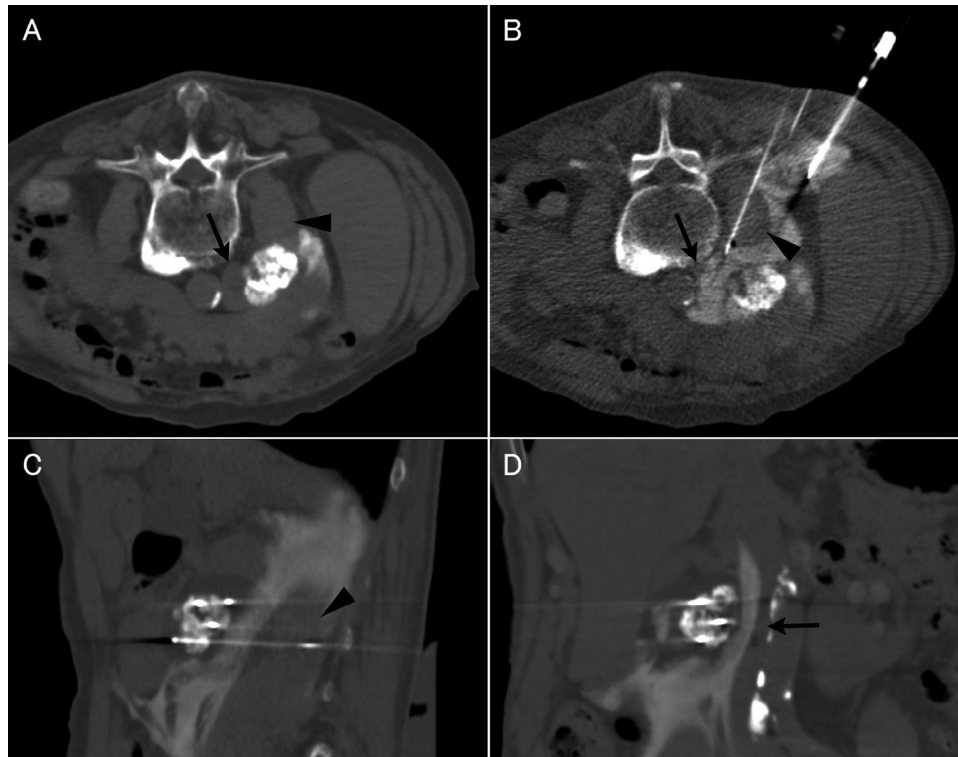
Percutaneous cryoablation under computed tomography (CT) guidance. (A) The patient was placed on the CT table in prone position. (B) Eighteen-gauge coaxial needles were punctured between the tumor and the inferior vena cava (IVC) (arrow) and between the tumor and the ascending colon. The IVC and iliopsoas muscle (arrowhead) were isolated from the tumor by hydrodissection. Cryoablation performed using 4 cryoneedles. (C) Sagittal image. (D) Coronal image. The ice ball, revealed as an area of low density, covered the entire tumor with several millimeters of safe margin.
